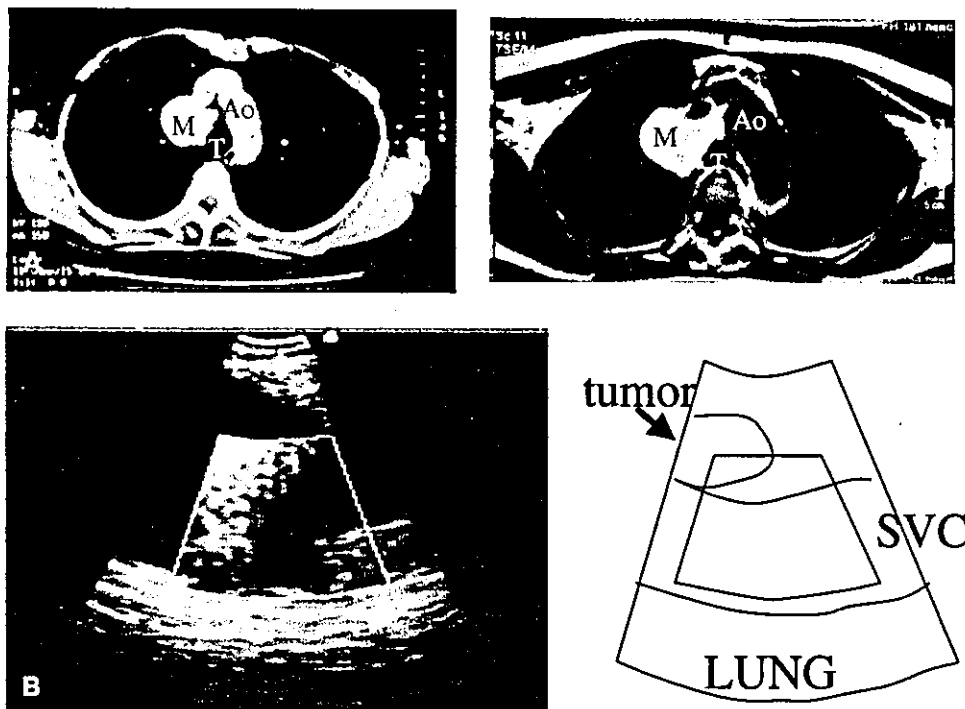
A, A chest computed tomographic scan demonstrated a mass (*M*) with high enhancement adjacent to the right wall of the trachea (*T*). Magnetic resonance imaging showed a mass with high intensity on the T1-weighted image. No flow void was observed. *Ao*, Aorta. Left, Chest computed tomographic image with mediastinal window. Right, T1-weighted image with magnetic resonance imaging of the chest. B, EBUS revealed the mass to be cystic, with high blood flow by the power Doppler mode. The area surrounded by the *white line* indicates the area subjected to power Doppler analysis.
